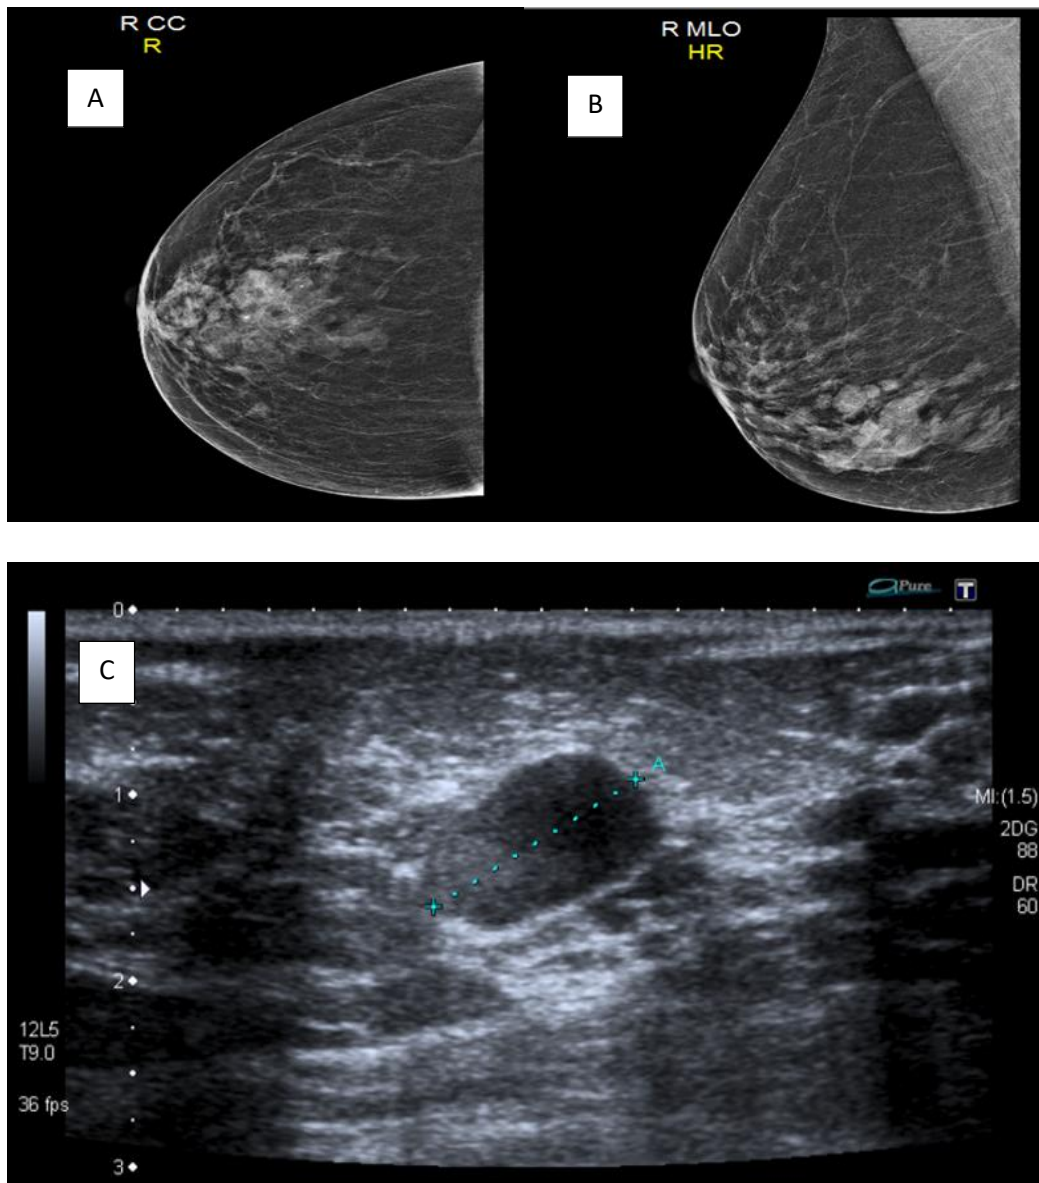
Above are images of a female patient with age above 40, clinical history of a palpable mass in the right breast. Images “A” and “B” are lobulated nodular changes retro areolar in a central position of the right breast on a mammogram CC and MLO views respectively. Image “C” demonstrates a sonographic evaluation. Inferolateral to the right nipple an ovoid solid nodular structure evident measuring 13 x 8 mm in size with a relatively vertical orientation containing complex fluid or is solid. (Medical Imaging, 2020).Printed with permission.
